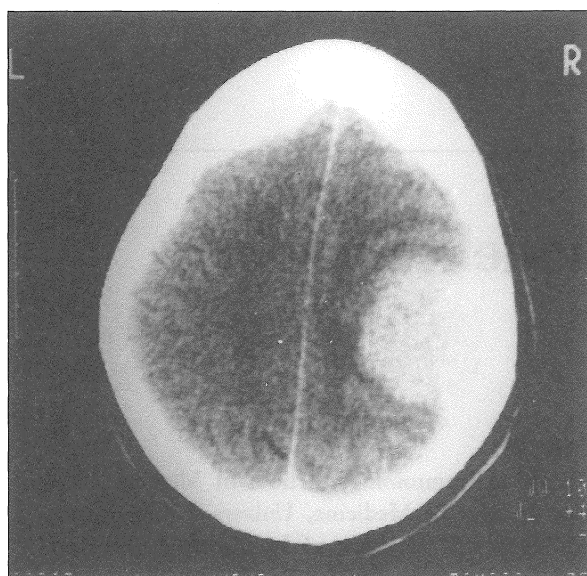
Computed tomography scan showing an enhanced extraaxial lesion in the right parietal region
